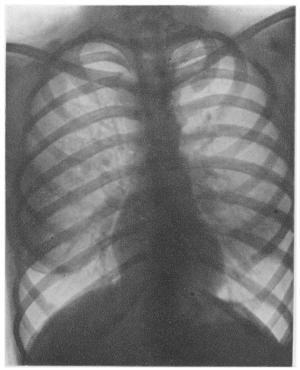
Radiograph taken January 12th, 1982.
